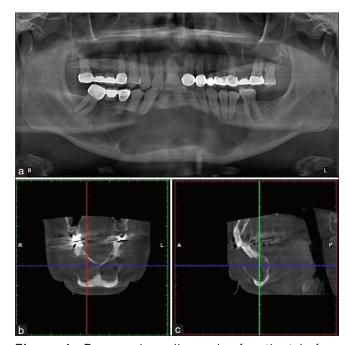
Panoramic radiograph of patient before marsupialization, showing a well-defined radiolucent area (a) coronal computed tomography (b) and sagittal tomography (c) showing weakened mandible and buccal and lingual expansions before treatment.
